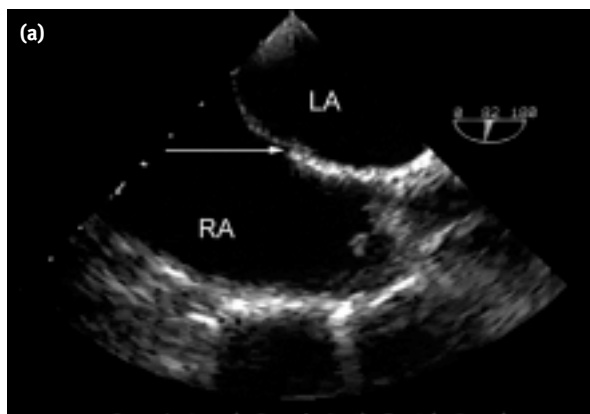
Transoesophageal echocardiogram showing (a) the flap valve PFO and micro-bubbles passing through it from right to left (b).
